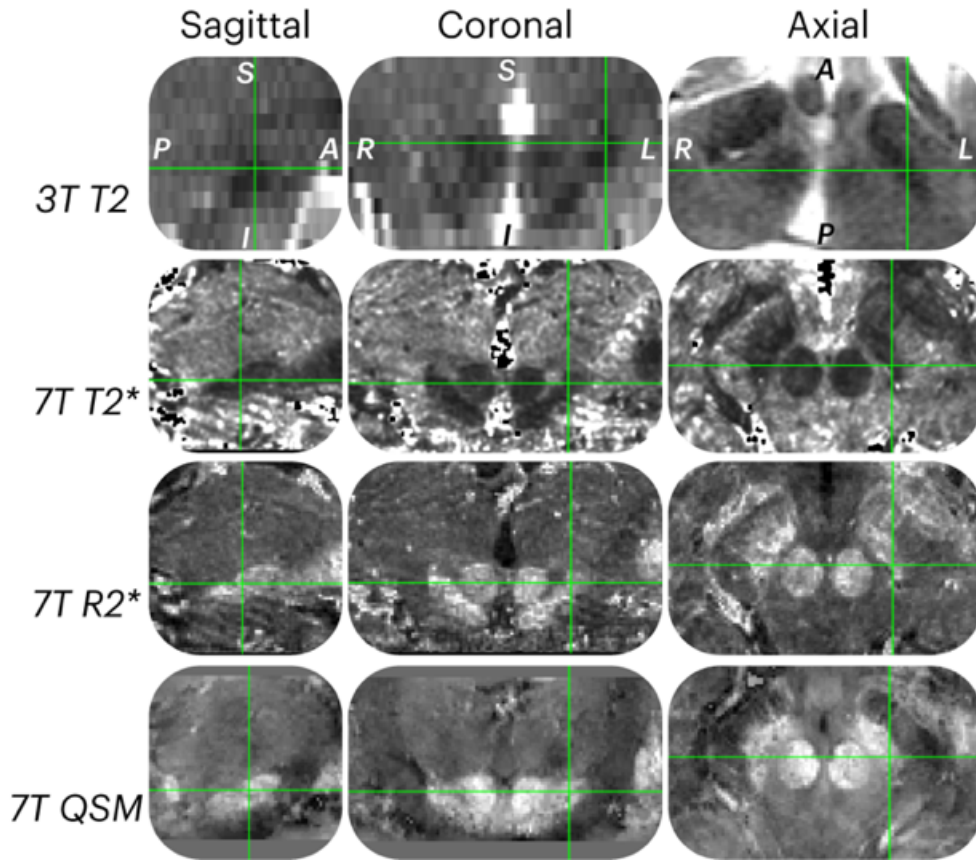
MRI image modalities. An example of each MRI image modality used for targeting for a single patient, including from top to bottom, a 3T-T2 weighted MRI, 7T-T2\* map, 7T-R2\* map and 7T Quantitative Susceptibility Map (QSM). The image shows a zoomed section of the subthalamic nucleus (STN) in the sagittal, coronal and axial planes. The STN is highlighted by the green intersection.
